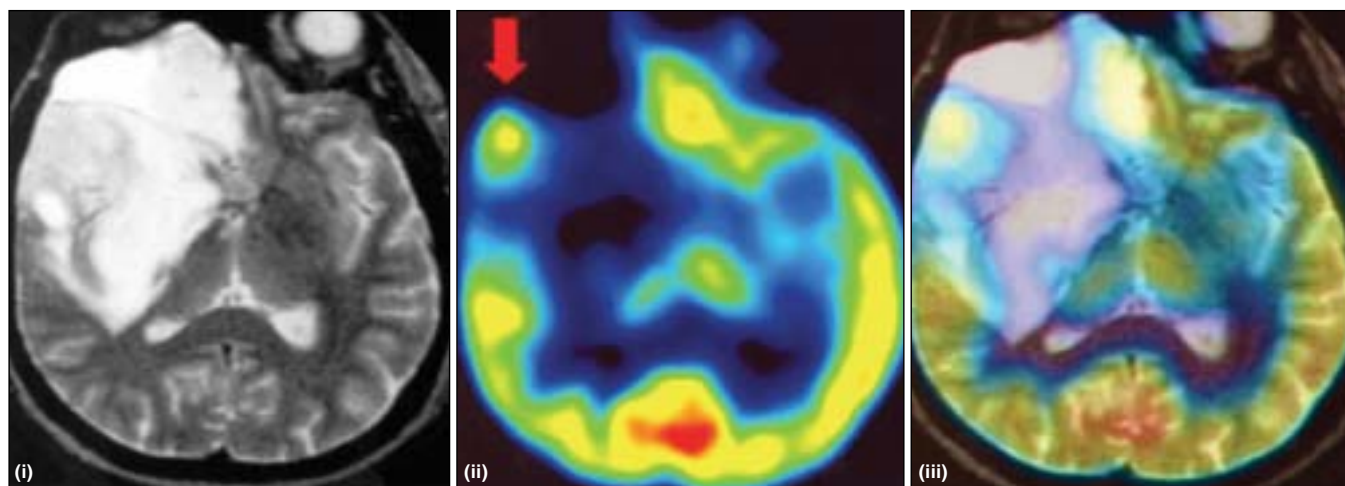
Neuroradiological features in 1996. The corresponding axial slice of MRT (i), ^{18}F FDG-PET (ii) and the merged co-registered scans (iii) made before second operation in 1996 after nine years from discovery. The red arrow points out the right temporal region of elevated ^{18}F FDG uptake. The surrounding part of the tumor is hypometabolic
